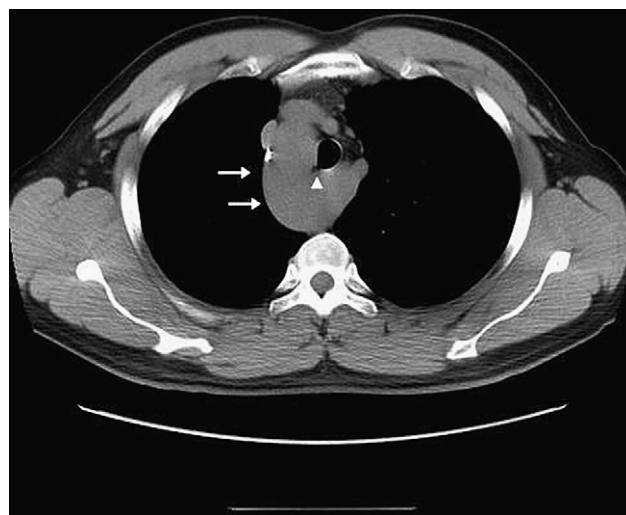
Chest computed tomographic scan shows a smooth-margined saccular structure (arrows) in the upper posterior mediastinum with mass effect over the esophagus (arrowhead).
